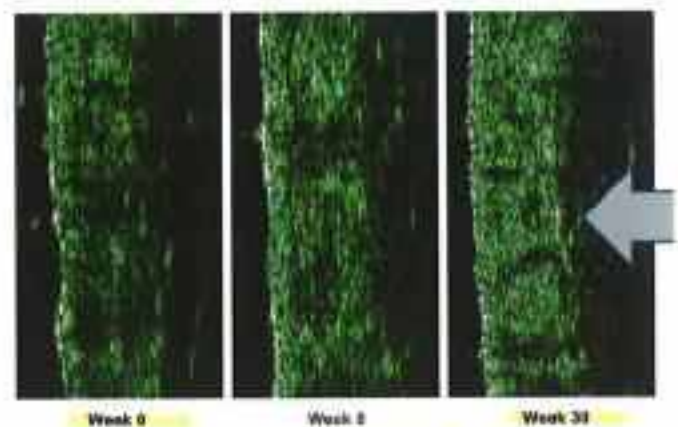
Increased dermal density over 30 weeks demonstrated by ultrasound imaging in a subject using the active regimen. Note the increase in echogenic substances in the dermal matrix over time.
